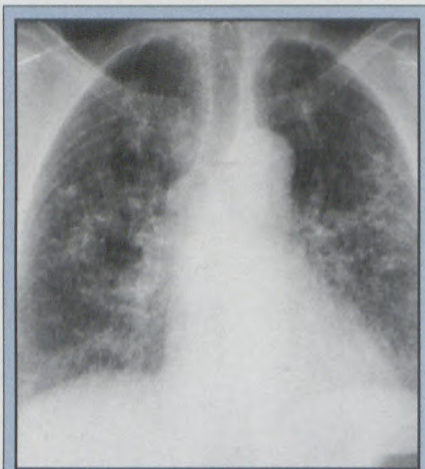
Chest radiograph of a 63-year old woman with hut lung. Nodules are of variable size and less profuse in the apices. Vascular clarity is lost.
